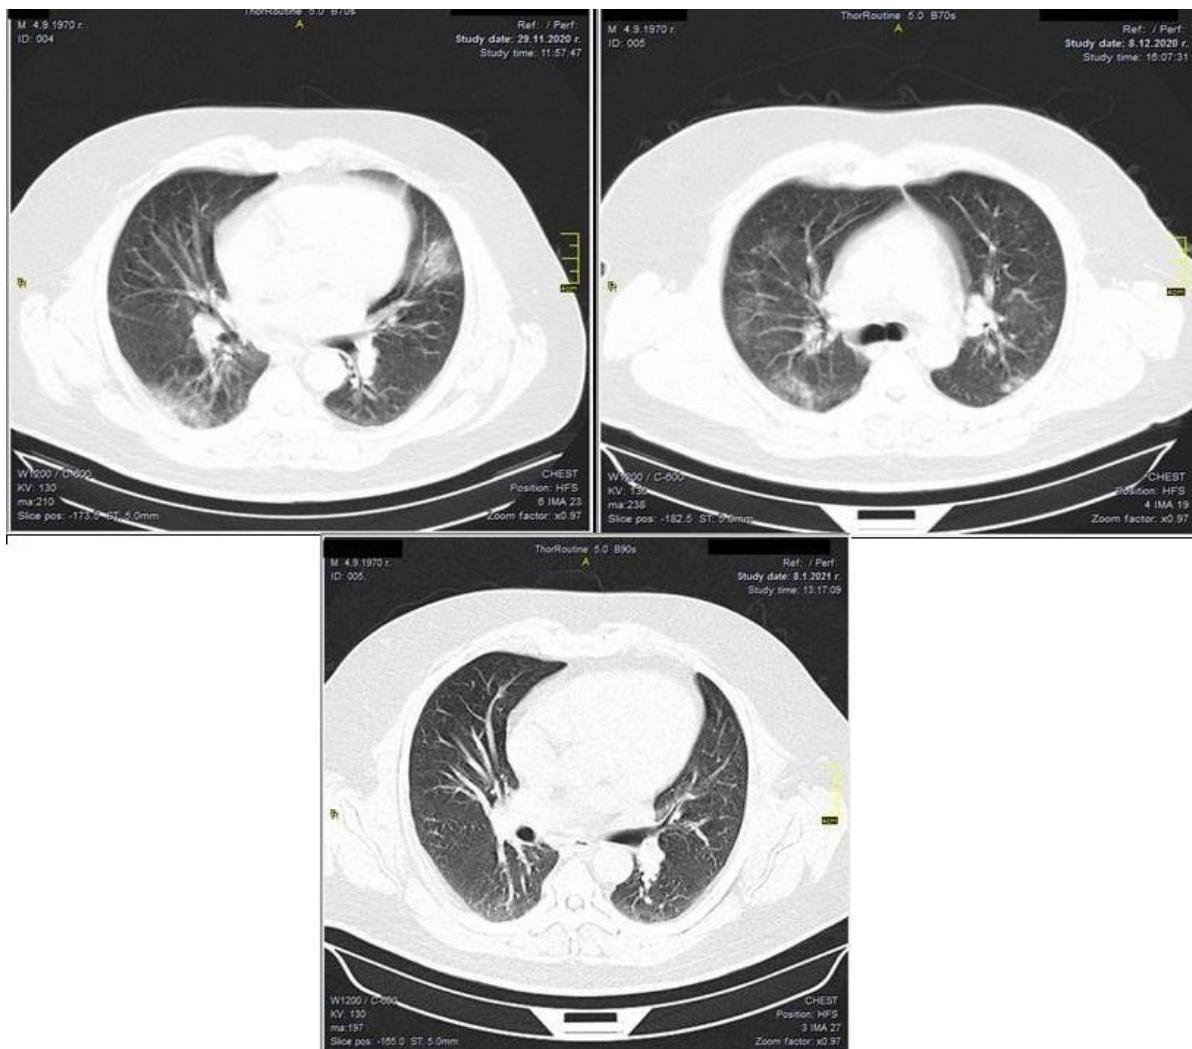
50-year-old patient with CT scan in dynamic in different stages of the disease – 5th day (GGO), 15th day (consolidation); 45th day (no lung changes).
